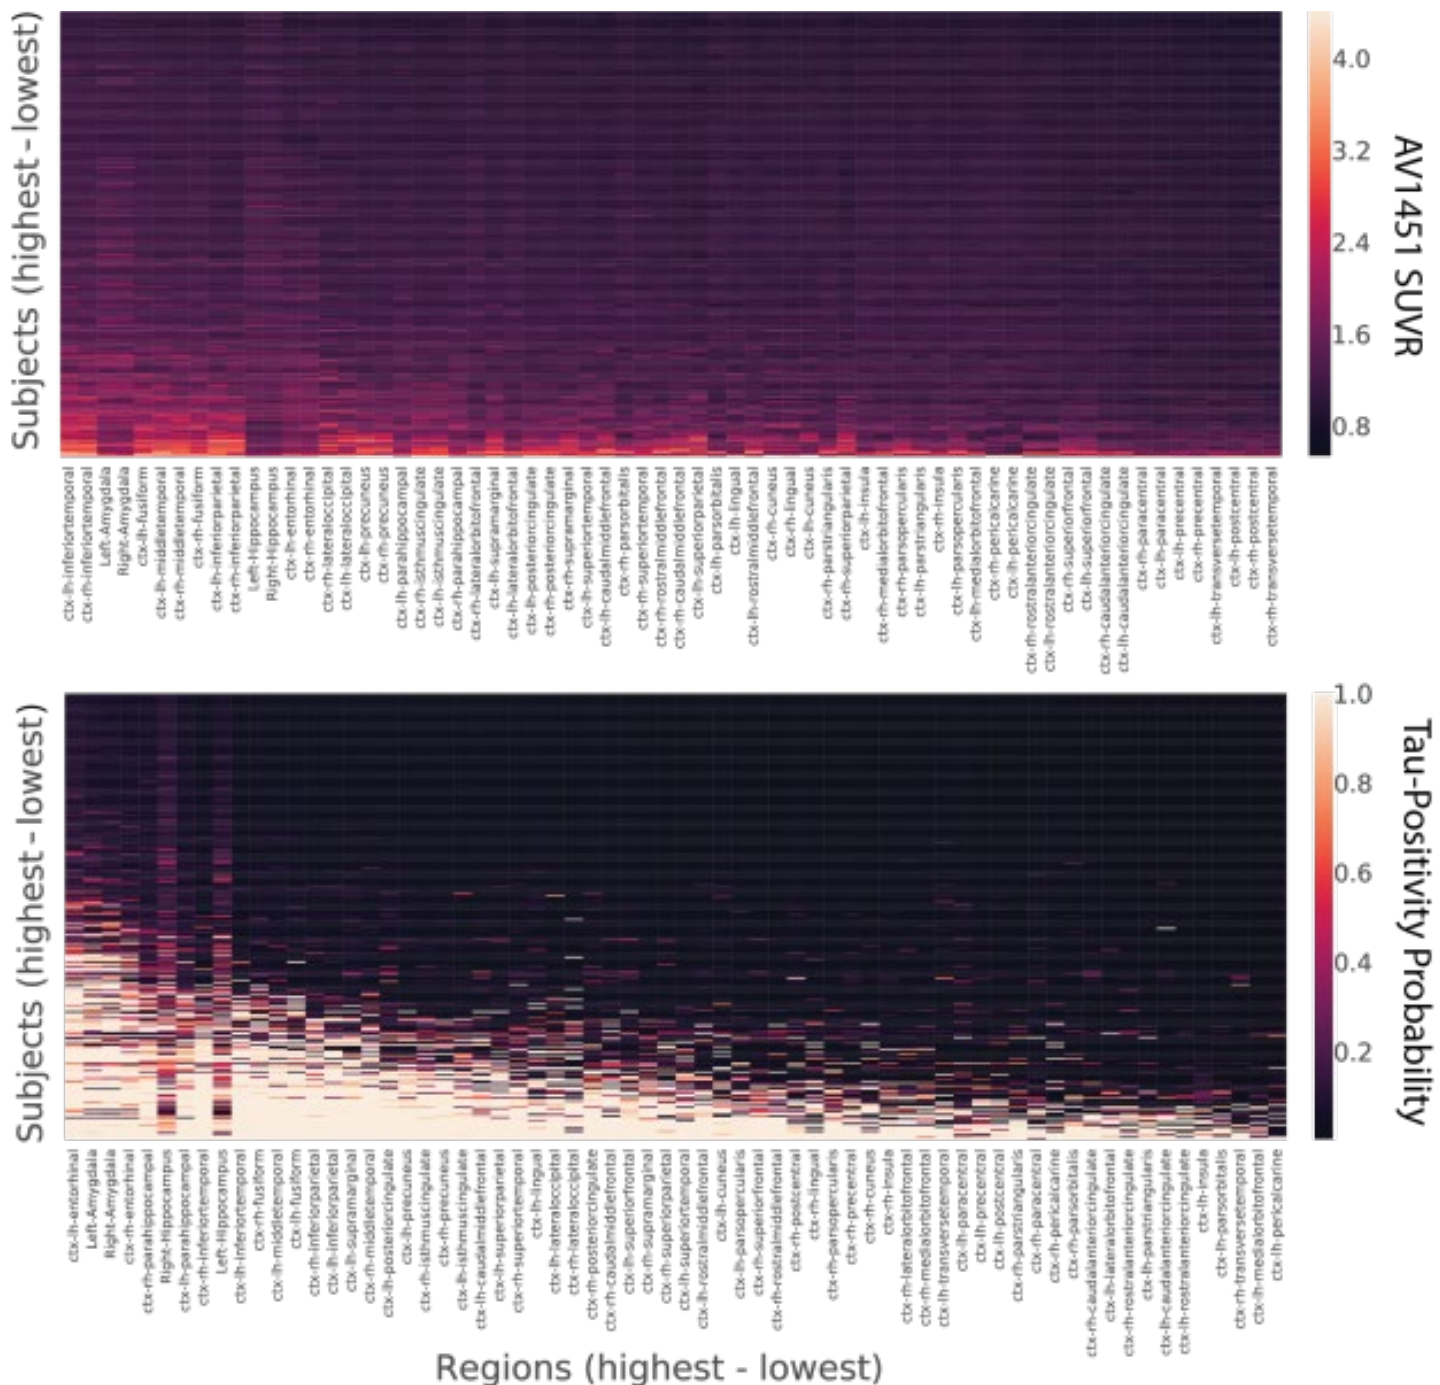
(Top) AV1451 SUVR values within each of the 66 ROIs (x-axis), for each of the 295 subjects (y-axis). Data is sorted to highlight a progression. (Bottom) The exact same data transformed using regional mixture modeling, and re-sorted based on the new values. Values represent the probability that a subject's SUVR falls on the rightmost of two gaussian distributions within a given ROI. This transformation clearly improves both the sparsity of the data, as well as the ordering of the ROIs in the progression.
